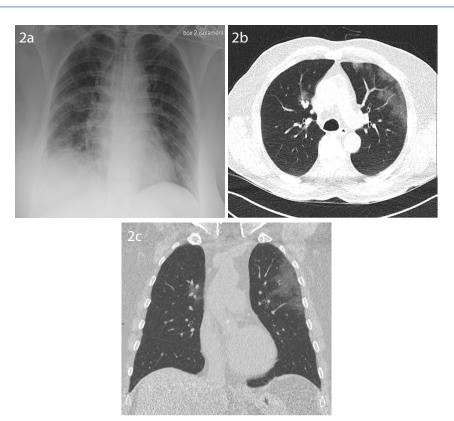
(A) Patient 3 Chest X-ray showed ill-defined infiltrates on the right mid and basal fields. (B and C) Diffuse bilateral infiltrates on uldCT (B and C).
